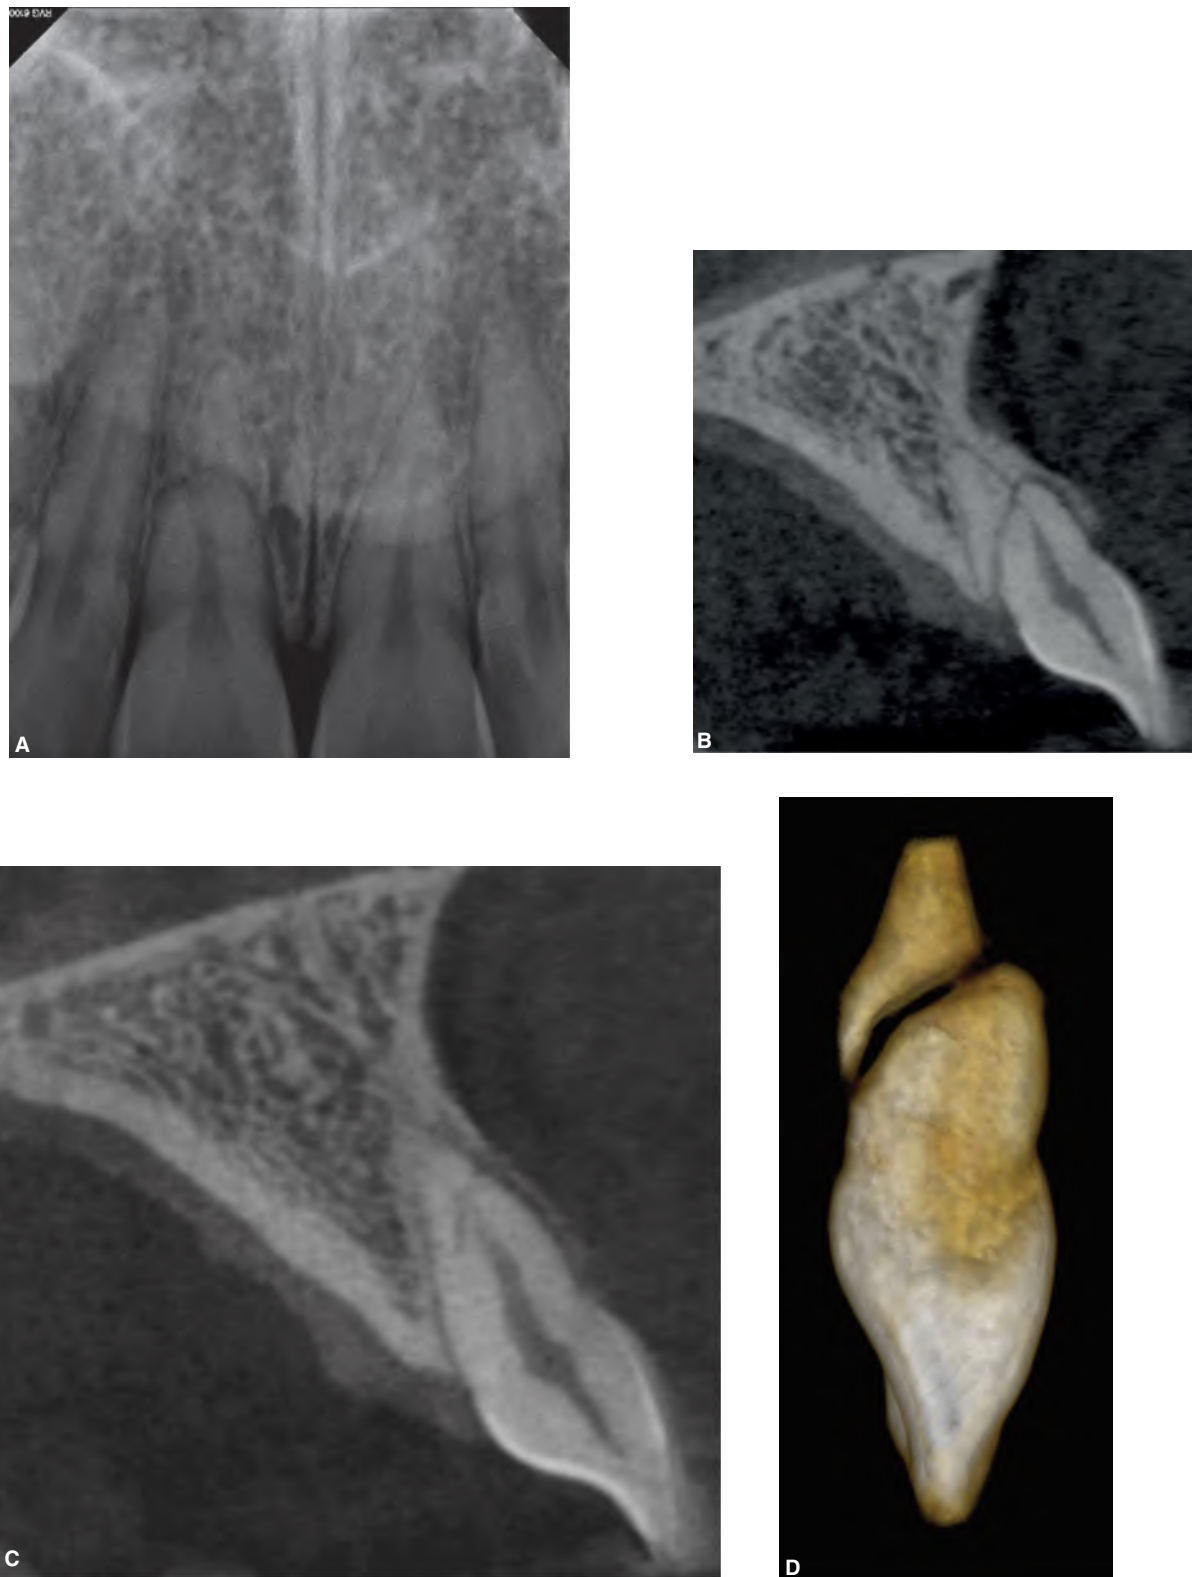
10 The sensitivity of CBCT is significantly higher than conventional imaging techniques in the detection of horizontal root fractures. A. Periapical radiograph showing a horizontal fracture in the middle third of the maxillary right central incisor with dislocated apical fragment. B. Sagittal reformation of the same tooth showing the true nature of the dislocation of the apical third of the root. C. Sagittal reformation of the maxillary left central incisor showing nondislocated oblique fracture of the apical third not clearly visible with periapical radiograph. D. Segmented 3-D CBCT reformation of the maxillary right central incisor.
